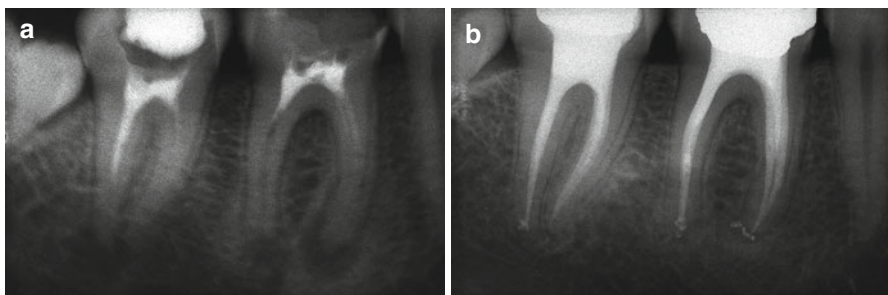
(a) Preoperative radiograph. The first and second lower molars were treated using just sealer as a root-filling material. (b) Two years follow-up
